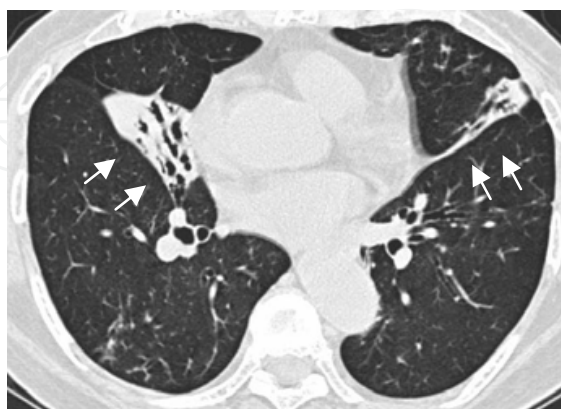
HRCT image of the lungs of a 72-year-old woman suffering from RA for five years (stage 3, class 2). No NTM were detected in several analysed sputum cultures. The level of anti-GPL core IgA antibodies was negative (0.26 IU/l). Bronchiectasis was seen in the right middle lobe and lingula with infiltration (arrows).
